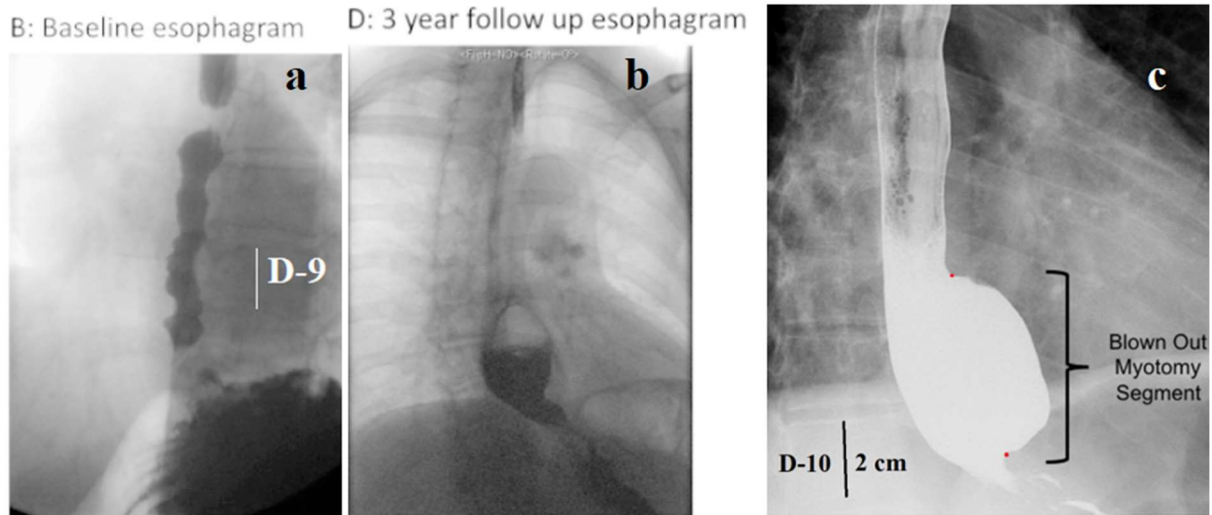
Radiographs from Triggs et al [38]. (a). Patient presented with dysphagia and chest pain and was referred for manometry. Manometry was consistent with Type III achalasia. The patient underwent POEM with a standard 9 cm myotomy. (b). The esophagram revealed a large pouch along the myotomy length that failed to empty consistent with a blown out myotomy. (c). Patient esophagrams were reviewed to assess for a BOM, defined as a distal wide-mouthed (>2 cm) diverticulum in the area of the prior myotomy with a greater than 50% increase in esophageal diameter.
